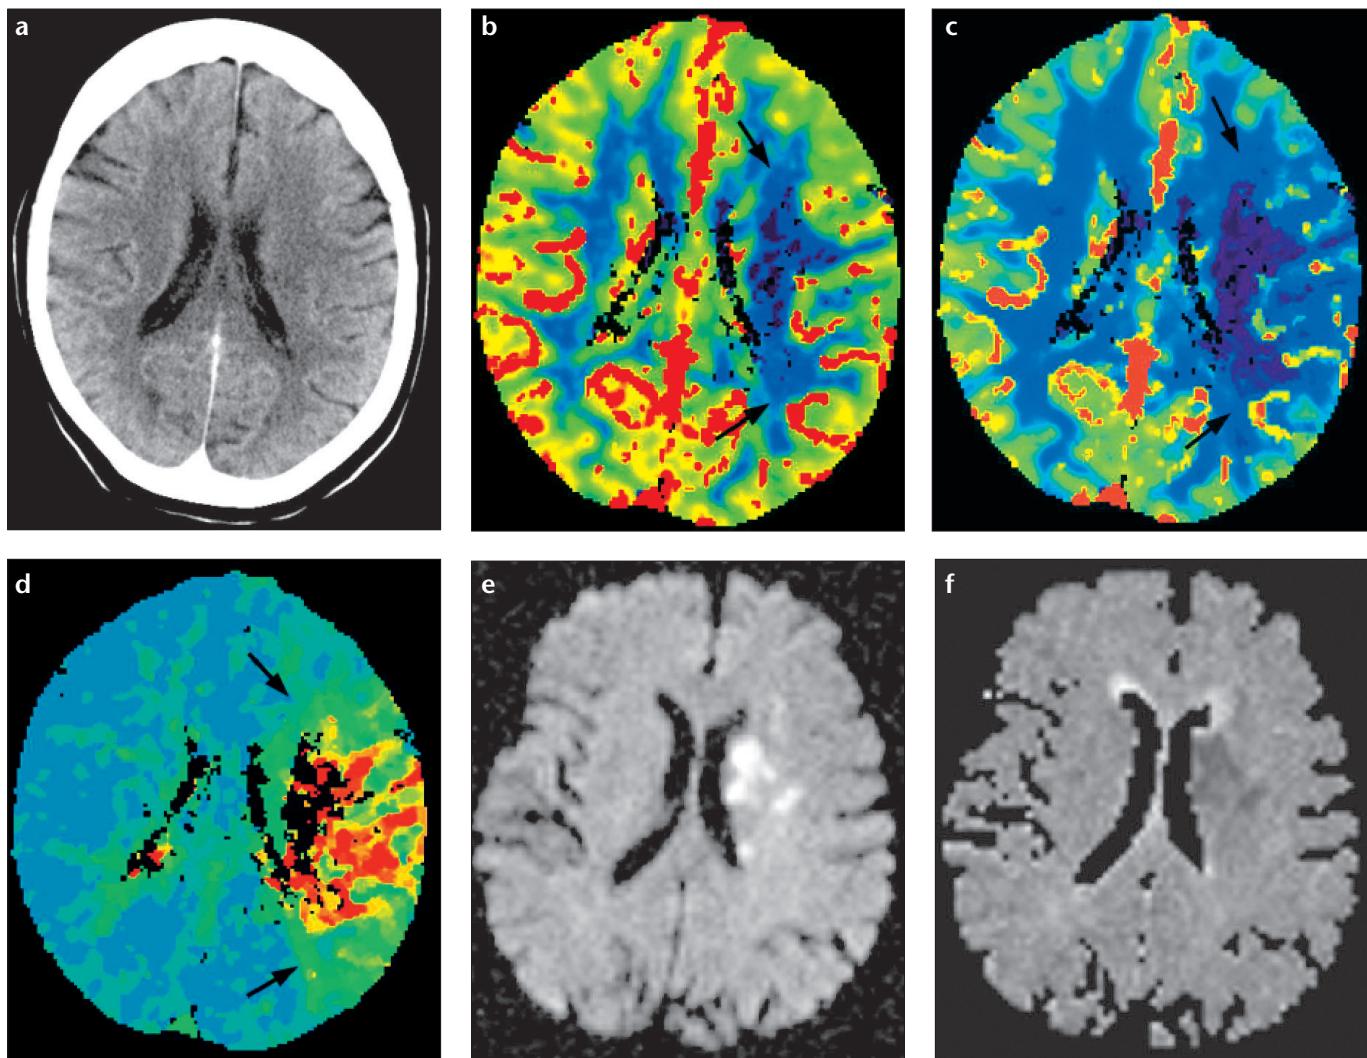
a-f. A 71 year-old female with right hemiparesis. No marked edema appearance consistent with acute infarct can be noted in the non-contrast axial brain CT image (a) through the lateral ventricles 3.5 hours after the onset of acute symptoms. Relative cerebral blood volume (b), relative cerebral blood flow (c) and time to peak (d) CT perfusion maps show large perfusion defect observed in the feeding area of the middle cerebral artery (arrows). Despite the wide perfusion defect observed on CT images, it was noted that tissue progressing to infarct has been arrested in the left corona radiata on a diffusion weighted MR image (e), and the corresponding apparent diffusion coefficient (ADC) map (f).
